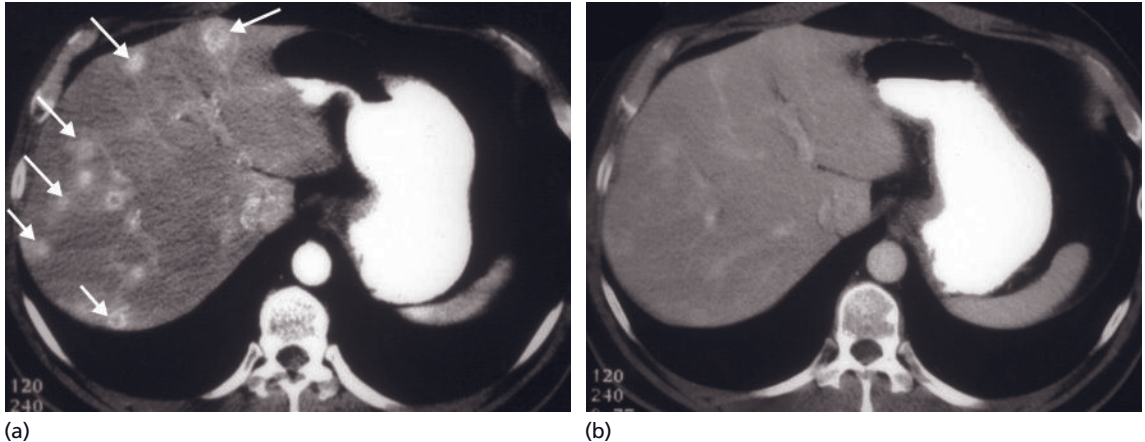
Hypervascular metastases. (a) Arterial phase CT image demonstrate numerous hypervascular metastases from a primary gastrointestinal neuroendocrine tumor (arrows). (b) Portal-venous phase image shows that the metastases have decreased enhancement and are nearly imperceptible. This is in contrast to hypovascular metastases which are best seen on the portal-venous phase images.
